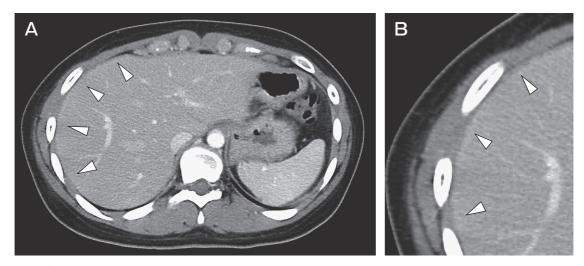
Contrast-enhanced CT image of the abdomen demonstrating a slightly enhanced hepatic surface (arrows).
